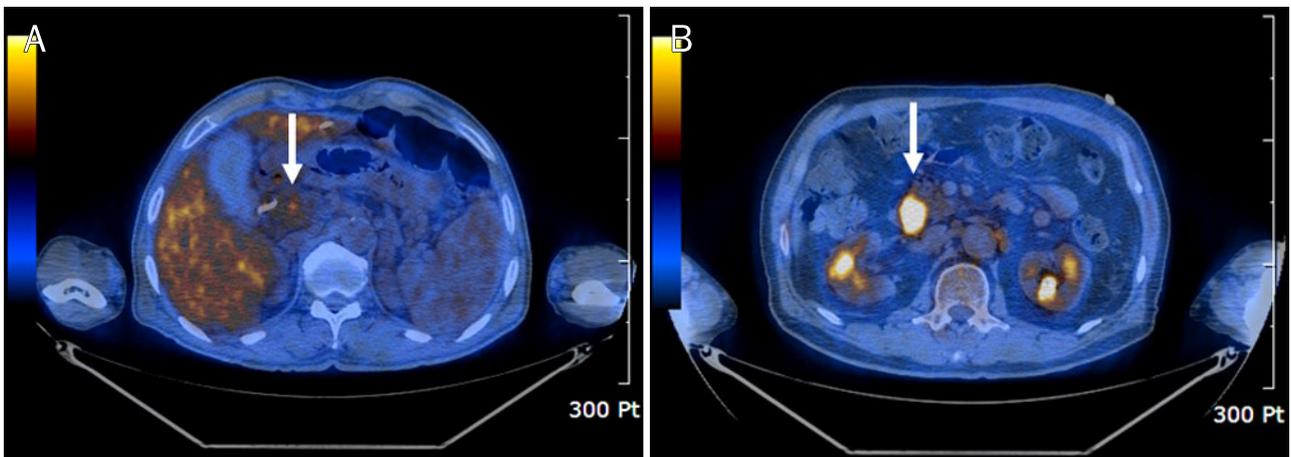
Axial FDG PET-CT images of two patients with common bile duct cancer who received nonsurgical treatment. Primary tumor maximum standardized uptake value is 3.1 (arrow) in 69-year-old man who was alive 26 months after diagnosis (A), and 9.9 (arrow) in 76-year-old man who died 10 months after diagnosis (B), respectively.
